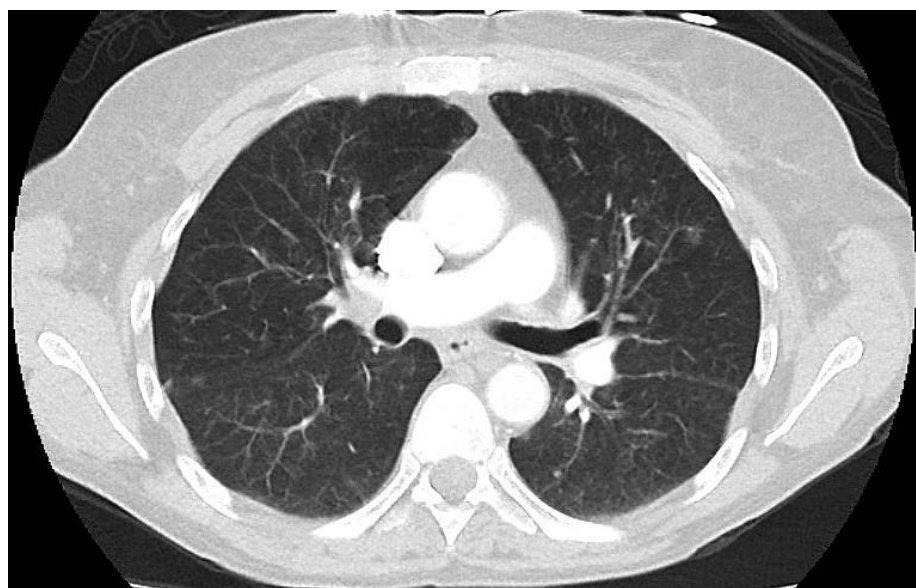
Initial contrasted chest computed tomography with minimal, peripheral, ground-glass opacities. No evidence of acute pulmonary emboli.
